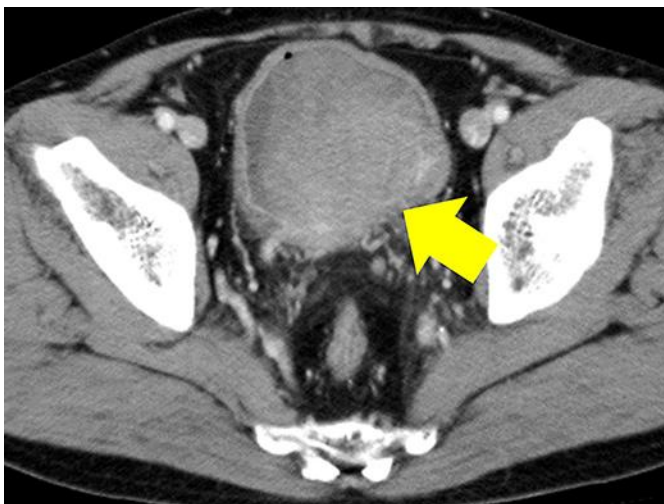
Contrast-enhanced CT image. The arrow indicates the tumor.
